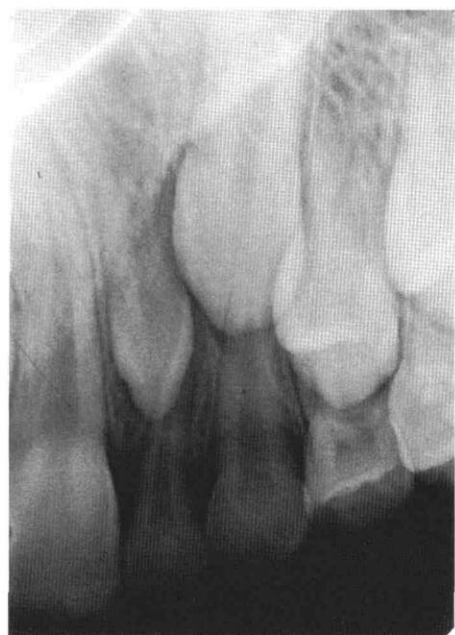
Periapical radiograph of pegged maxillary left permanent lateral incisor.
